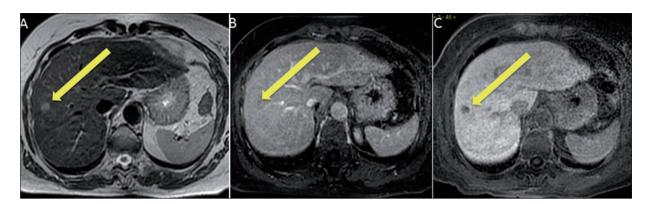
Liver metastasis. *A,* Axial T2-weighted image shows in the VIII hepatic segment a centimetric hyperintense lesion. *B,* In the portal phase after contrast injection, the lesion is barely visible. *C,* In the hepatobiliary phase, an hypointense nodule is clearly visible.
